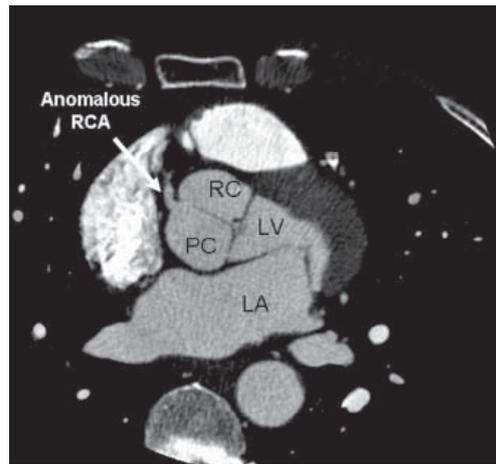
Computed tomography confirms the right coronary artery is arising from the posterior coronary sinus. LA: left atrium; LV: left ventricle; PC: posterior coronary sinus; RC: right coronary sinus; RCA: right coronary artery.
